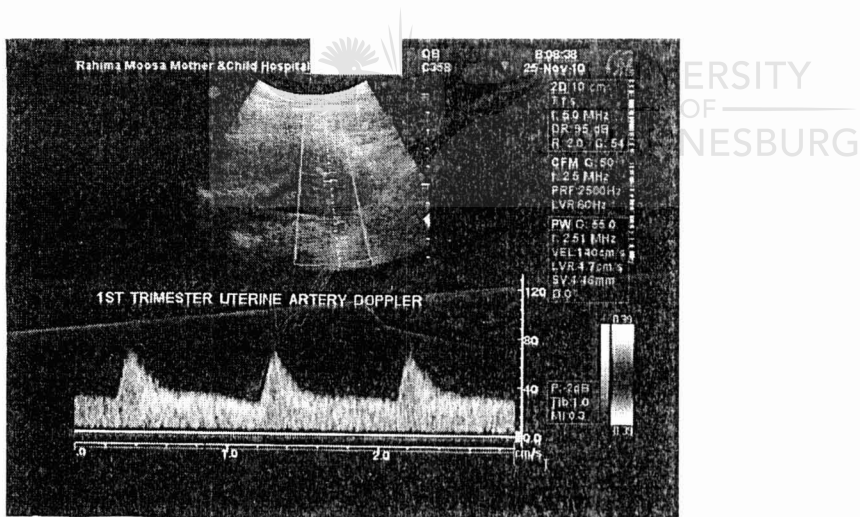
Demonstrating a normal 1st trimester uterine artery Doppler (Researchers collection)
